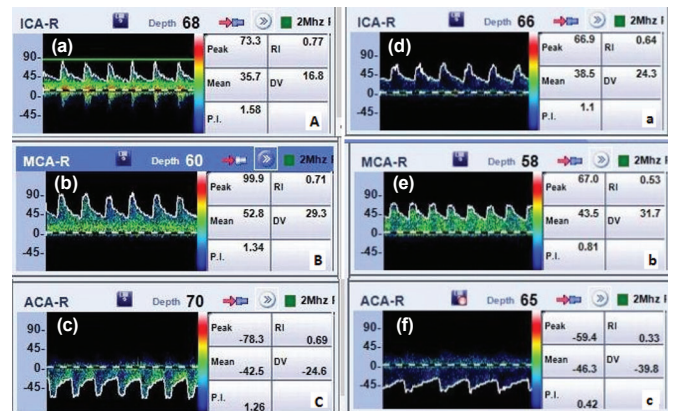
Transcranial doppler (TCD) spectrum in stroke patient (a) for right internal carotid artery (ICA-R), (b) for right middle cerebral artery (MCA-R), (c) for right anterior cerebral artery (ACA-R). TCD spectrum in normal person (d) for ICA-R, (e) for MCA-R, and (f) for ACA-R. Significance of blue, red and green colour: When the wave spectra display shows a mixture of colours (mosaic appearance), such as red, blue, yellow, and green, this usually suggests increased velocity variability or turbulence in the artery
